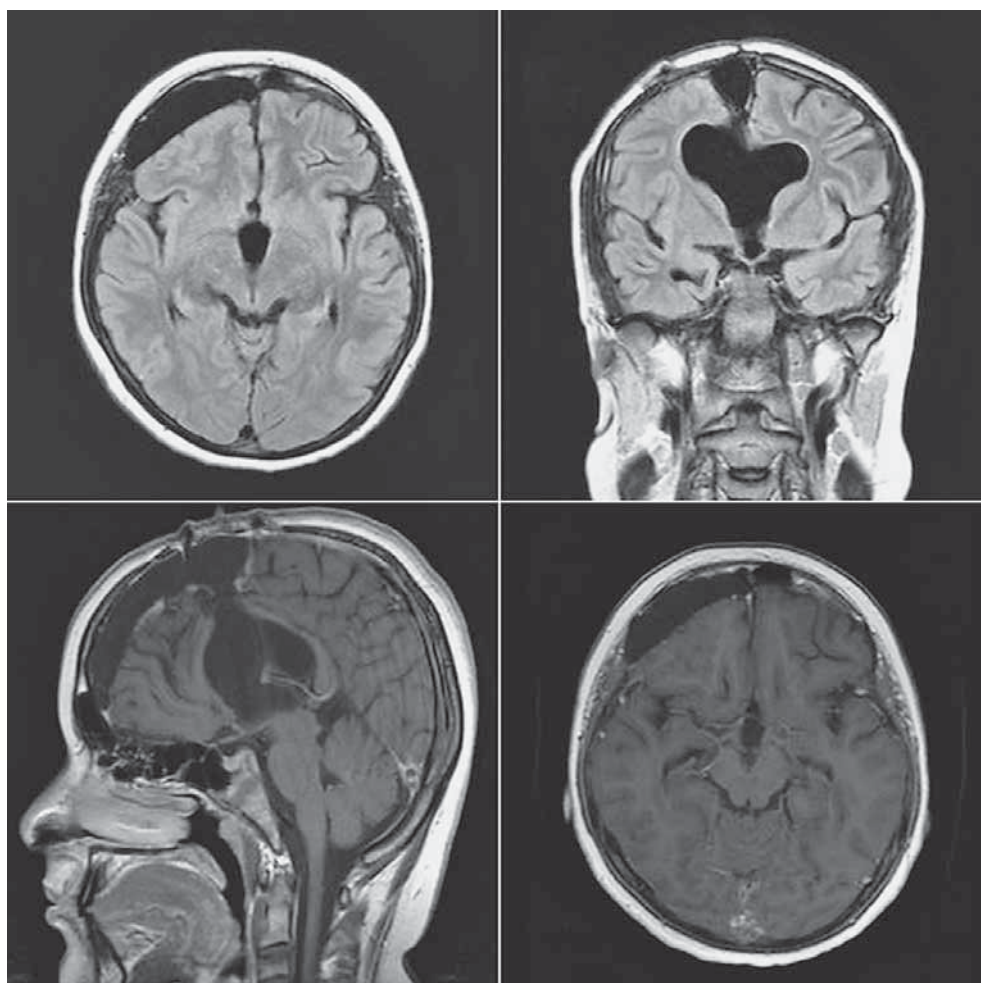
MRI acquired a month after the surgery showing complete tumor removal without new neurosurgical complications.
